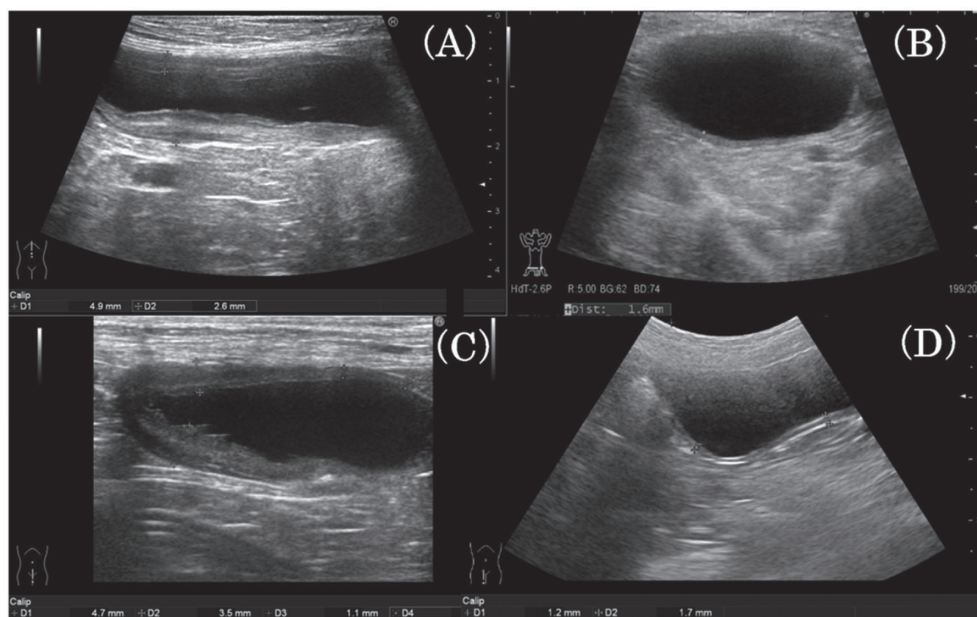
Abdominal ultrasonographic images of the bladder. A. The bladder wall appeared severely thickened around the circumference, and mucosal surface irregularity is noted at initial presentation; B. Hematuria and thickening of the bladder wall showing improvement after initiating chemotherapy with nimustine on day 20; C. Recurrence of bladder wall thickening can be observed on day 125; D. Thickening of the bladder wall cannot be observed on day 328.
